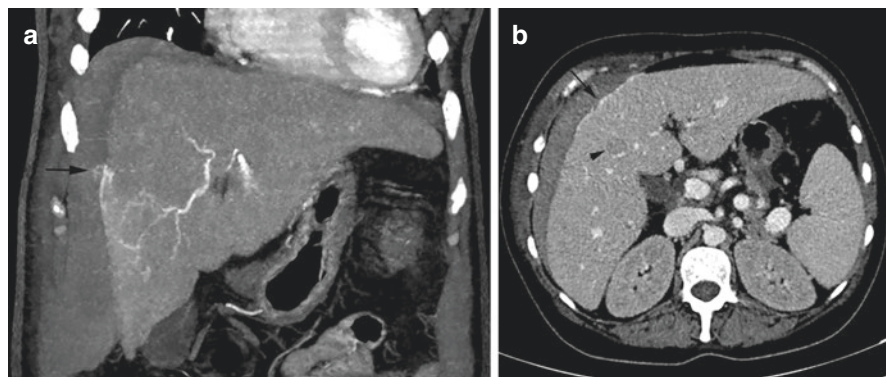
Active biopsy site contrast extravasation in patient with multiple myeloma. (a) coronal maximum intensity projection, and (b) axial contrast enhanced CT images show active extravasation (*black arrow*) from the liver surface, with adjacent hematoma. Multiple hypo enhancing liver lesions also noted
